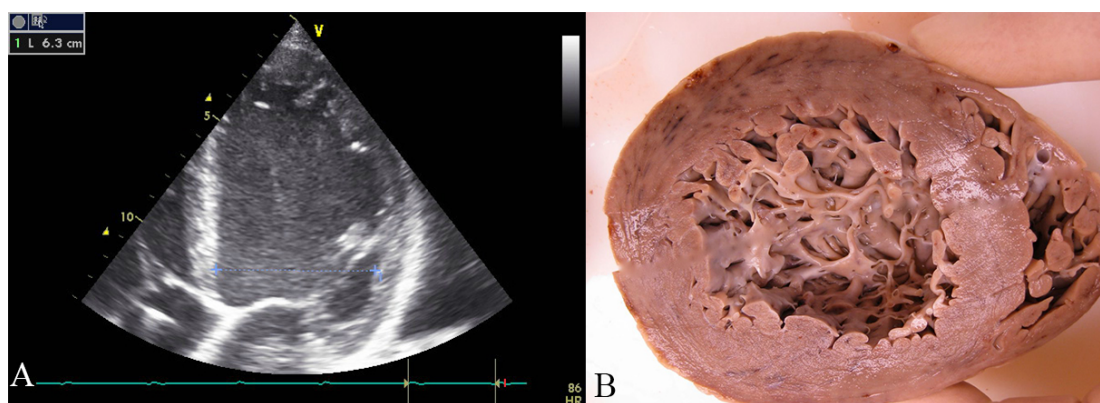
Echocardiographic and pathoanatomic picture of left ventricular hypertrabeculation/noncompaction. (A) Echocardiographic apical four-chamber-view of a patient with dilated cardiomyopathy. Four trabeculations are visible in the apex of the left ventricle, thus fulfilling the criteria of Stöllberger *et al.* [10] for left ventricular hypertrabeculation/noncompaction. (B) One week after echocardiography, the patient died due to heart failure. The formaldehyde-fixed heart is opened along the short axis. A heavily trabeculated apical portion of the left ventricle is visible.
